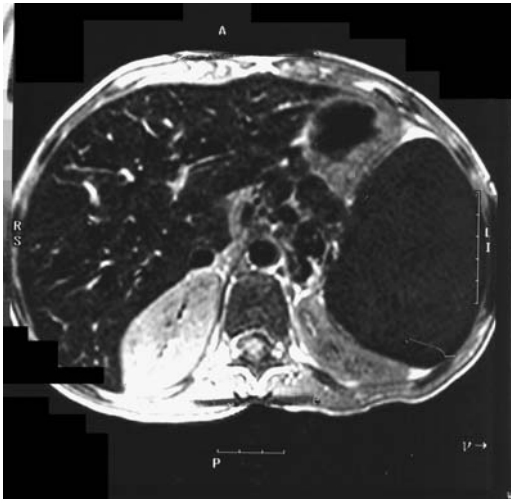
Iron overload in a 10-year-old with sickle cell disease and multiple transfusions. MR shows a markedly hypointense liver and spleen. (Source: Burgener FA, Meyers SP, Tan RK, Zaunbauer W. *Differential Diagnosis in Magnetic Resonance Imaging*. Stuttgart: Thieme, 2002, with permission.)
